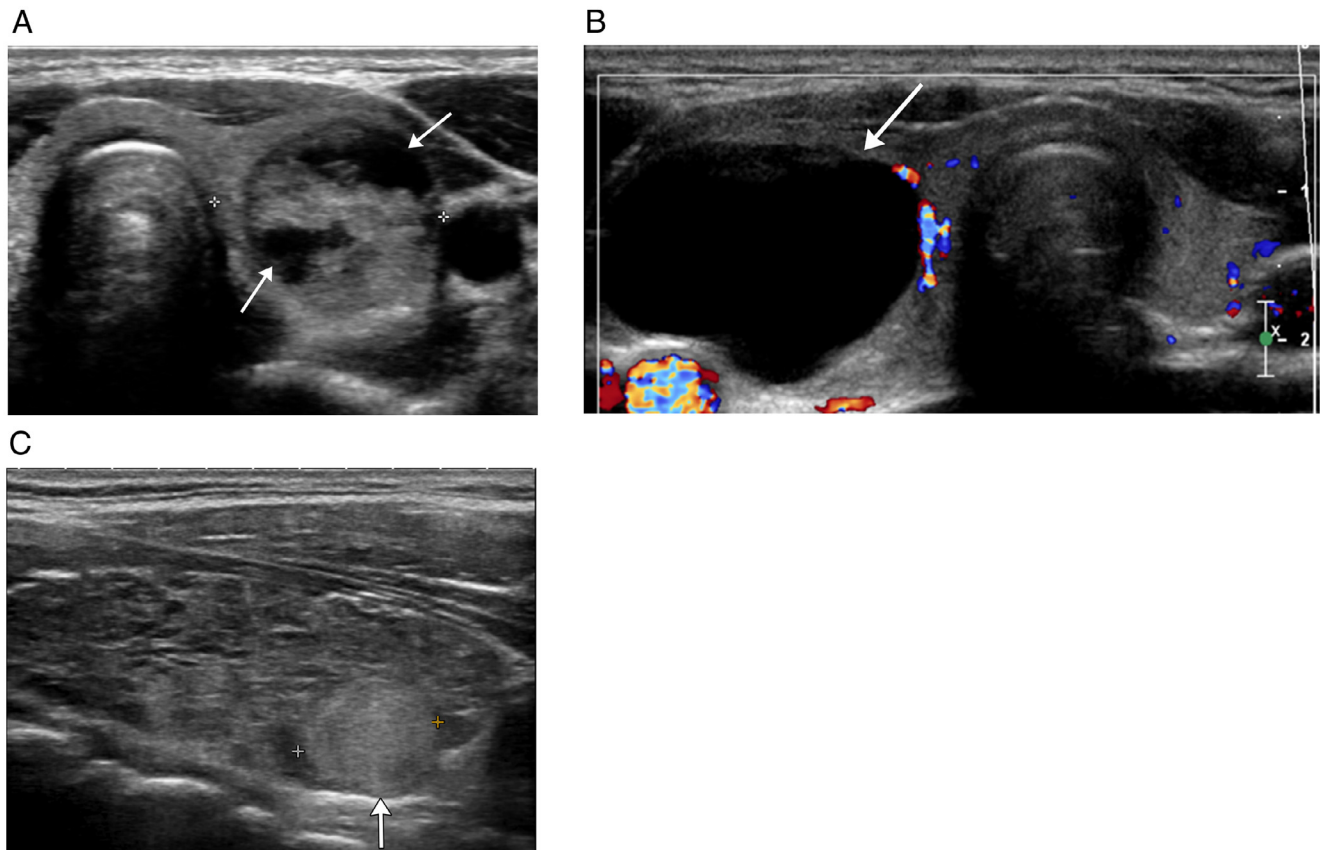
Benign thyroid nodules depicted on ultrasound. A. Hyperplastic nodule (proved on fine-needle aspiration) in an 11-year-old girl. The nodule is composed of echogenic areas interspaced with anechoic foci of presumed liquefaction (arrows). B. Presumed colloid cyst in a 14-year-old girl. The nodule (arrow) is entirely anechoic, with no solid components. C. Hashimoto disease in a 17-year-old boy. Well-defined diffusely hyperechoic nodule (arrow) in the lower pole of the left lobe in a background of diffusely heterogeneous thyroid parenchyma. A diffusely hyperechoic nodule in the setting of thyroiditis is invariably benign, commonly representing a regenerative nodule.
